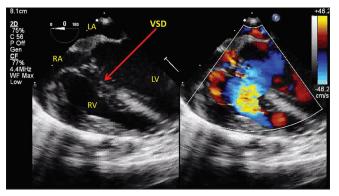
Trans-esophageal echocardiography mid-esophageal view, 0°, with color doppler showing inlet type of ventricular septal defect (VSD; red arrow). LA: Left atrium; LV: Left ventricle; RA: Right atrium; RV: Right ventricle
